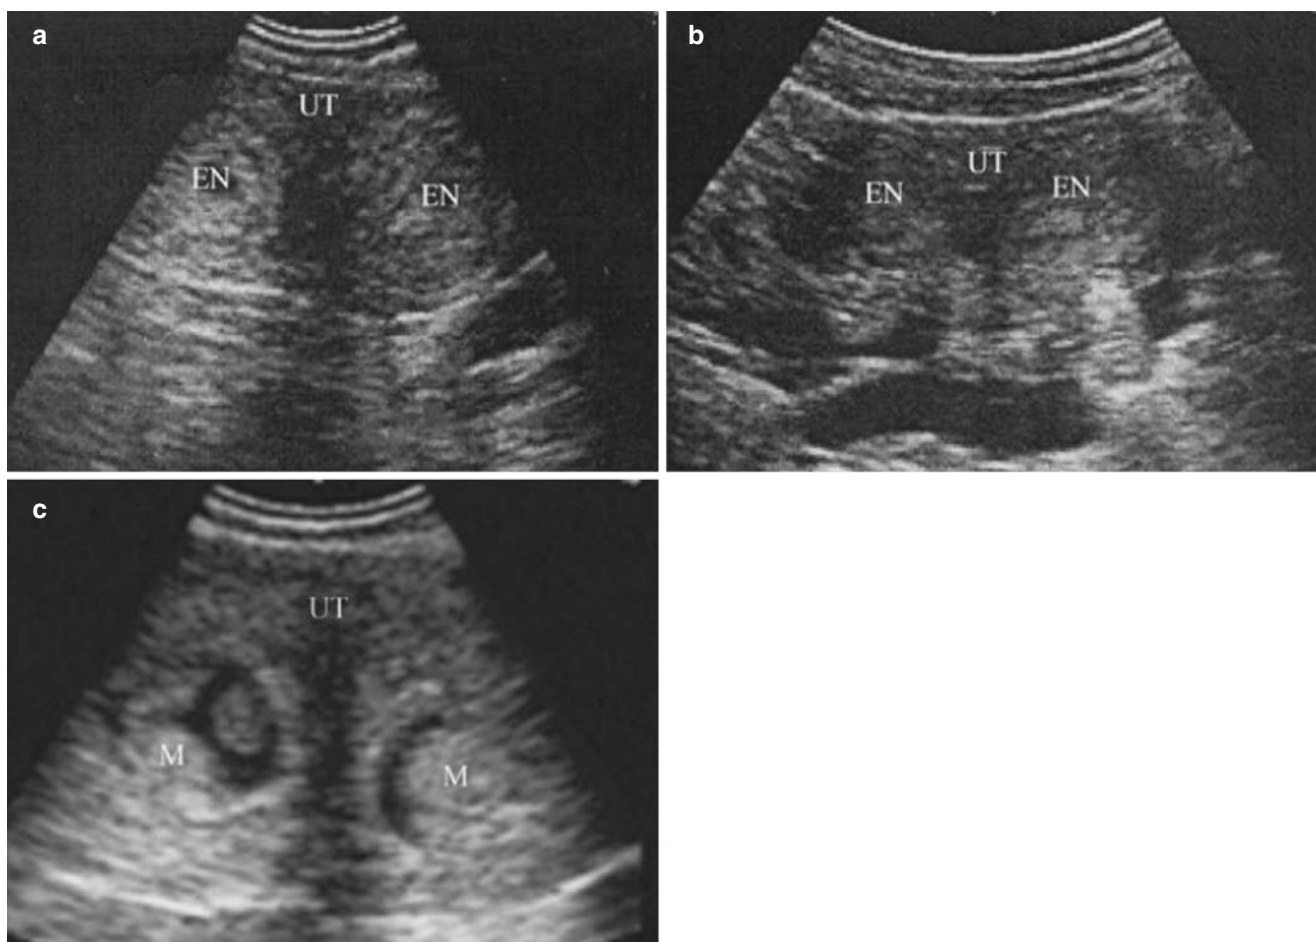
Sonohysterography of multiple endometrial polyps combined with incomplete uterus septum. (a) The patient is 27 years old, who was diagnosed with primary infertility. The manifestation of ultrasound shows two separate uterine cavities, with thickened and inhomogeneous endometrium. (b) The transverse view of the uterus shows two
